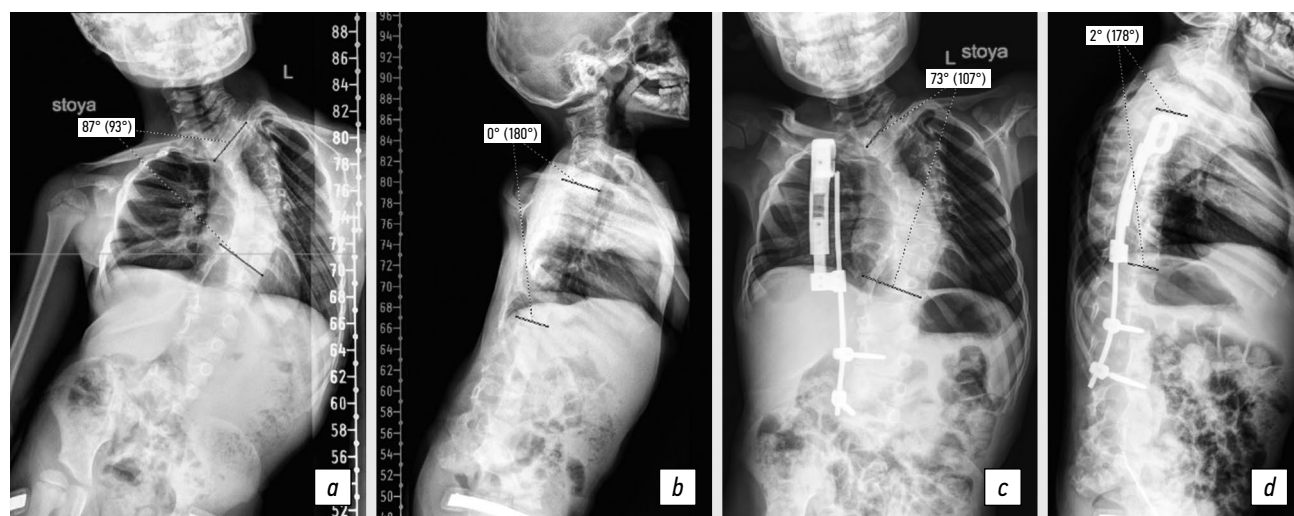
Panoramic radiograph of the spine in frontal and lateral projections before and after the surgical treatment. Patient, 6 years old: *a, b*, scoliosis before the surgery (87°), lordosis of the thoracic spine (0°); *c, d*, scoliosis after the surgery (73°), kyphosis (2°)
